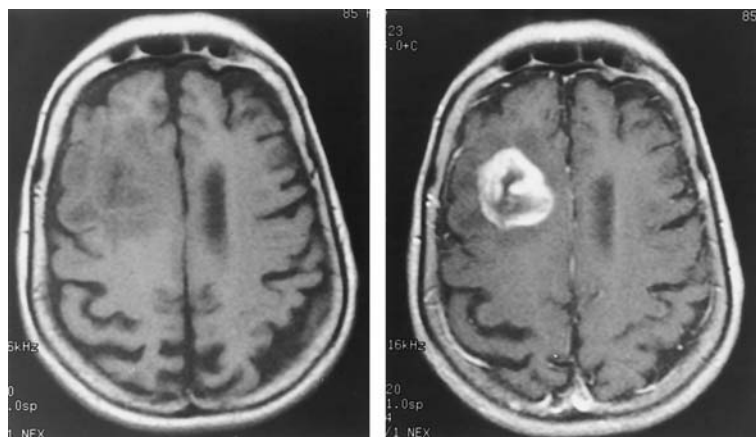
Axial T1-weighted images without (left) and with (right) gadolinium enhancement in an immunocompetent patient with primary CNS lymphoma. The ring enhancing lesion could also be metastasis, malignant glioma or even abscess.
